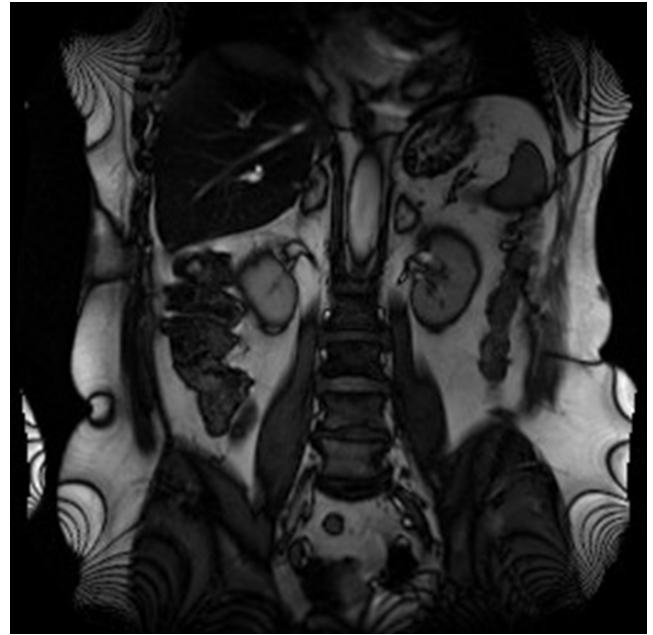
Patient No. 3: bilateral adrenal hemorrhage; the lesions are 50 mm in diameter (MRI)
